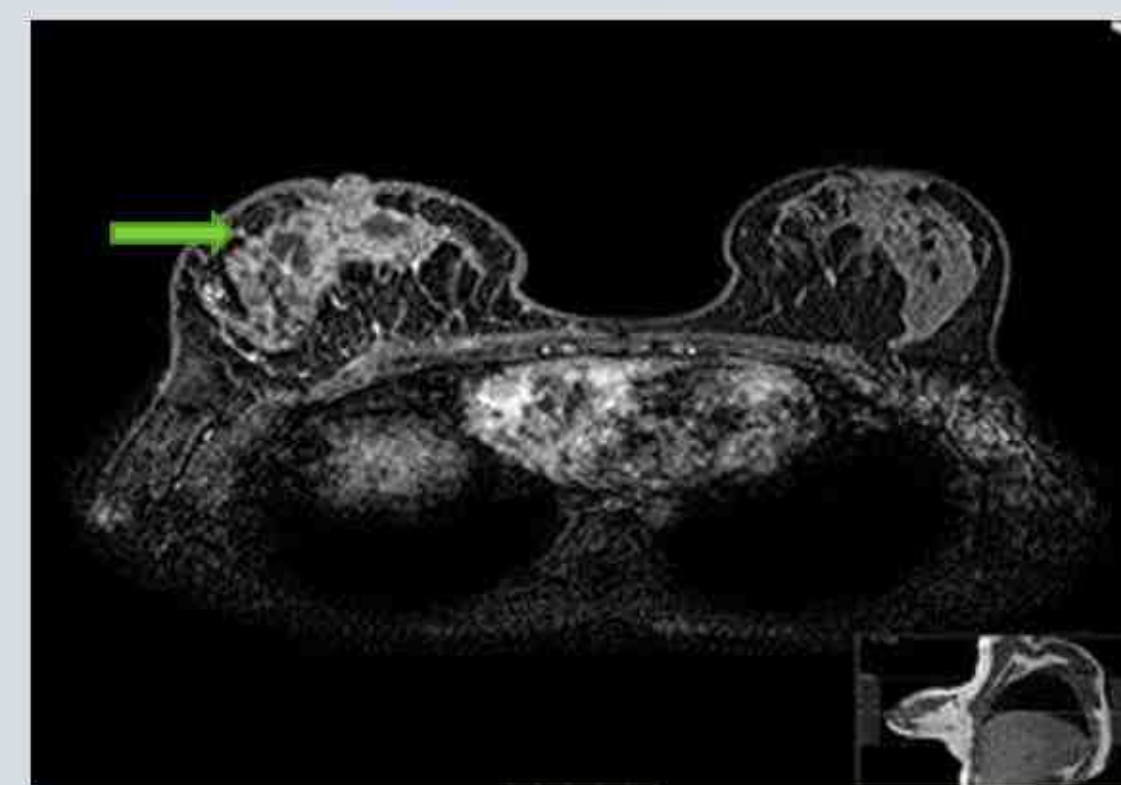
(Right) Axial MRI demonstrates an ill defined enhancing mass within the right breast (arrow) found to be TB mastitis on sampling.
